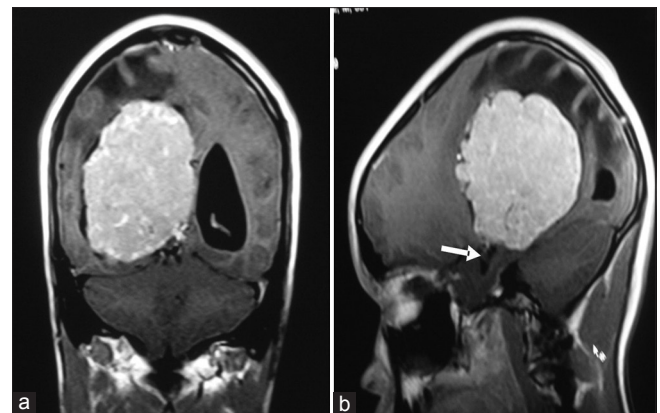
T1-weighted post contrast coronal (a) and sagittal (b) Magnetic resonance imaging showing avid contrast enhancement and enlarged lateral ventricles due to outflow obstruction
